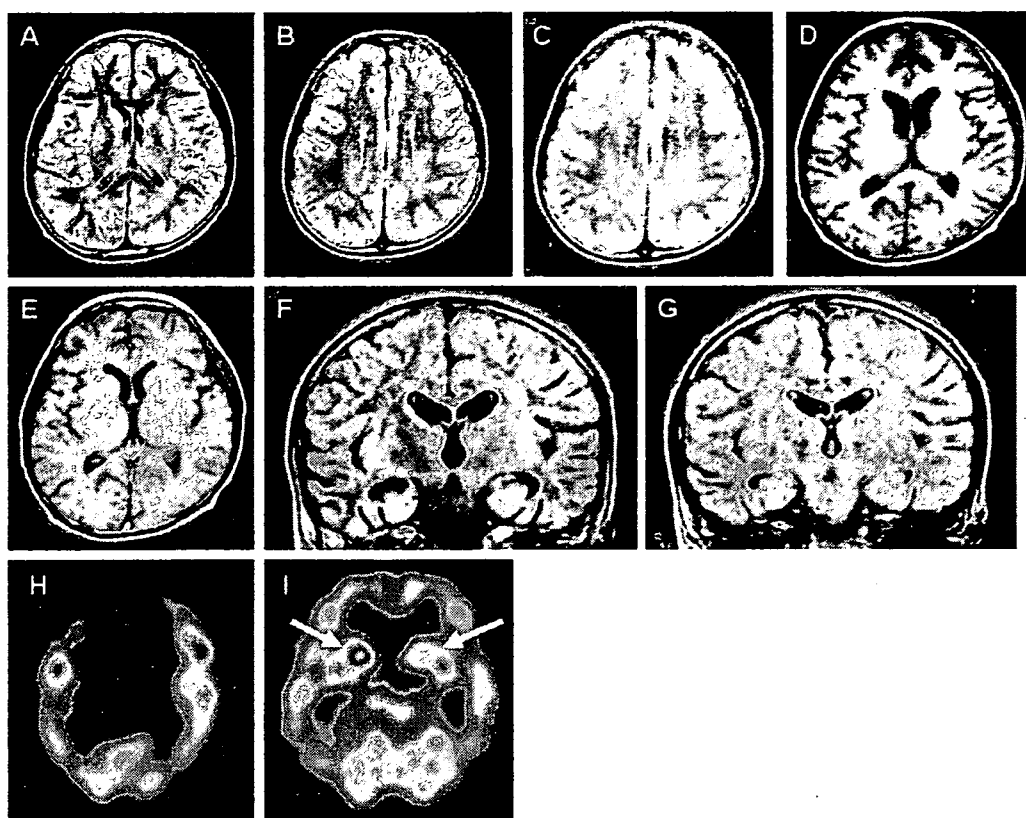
Neuroimaging of the patient. Magnetic resonance imaging (MRI) [A–C, F, and G: fluid-attenuation inversion recovery (FLAIR) images; (D) and (E), T1-weighted images] and single photon emission-computed tomography (SPECT) (H and I) of the patient. On day 14 of illness (A and B), multiple cerebral cortical lesions were distributed in the cerebral cortex, predominantly in the left parietal and bilateral frontal lobes. White matter, basal ganglia, thalamus, cerebellum (not shown), and brainstem were spared. On day 34 (C), cortical lesions (B) almost disappeared on FLAIR imaging. On day 61 (D and F), diffuse cerebral cortical atrophy with predominance in the frontal lobes (D) and hippocampus (F) was noted. On day 117 (E and G), the cortical atrophy had almost disappeared (E) but the hippocampal atrophy remained (G). On day 10, hyperperfusion was apparent in the left frontal, parietal, and right frontal lobes (H), consistent with high-signal lesions (B). On day 80, hyperperfusion appeared in the bilateral hippocampus (I, arrows).
